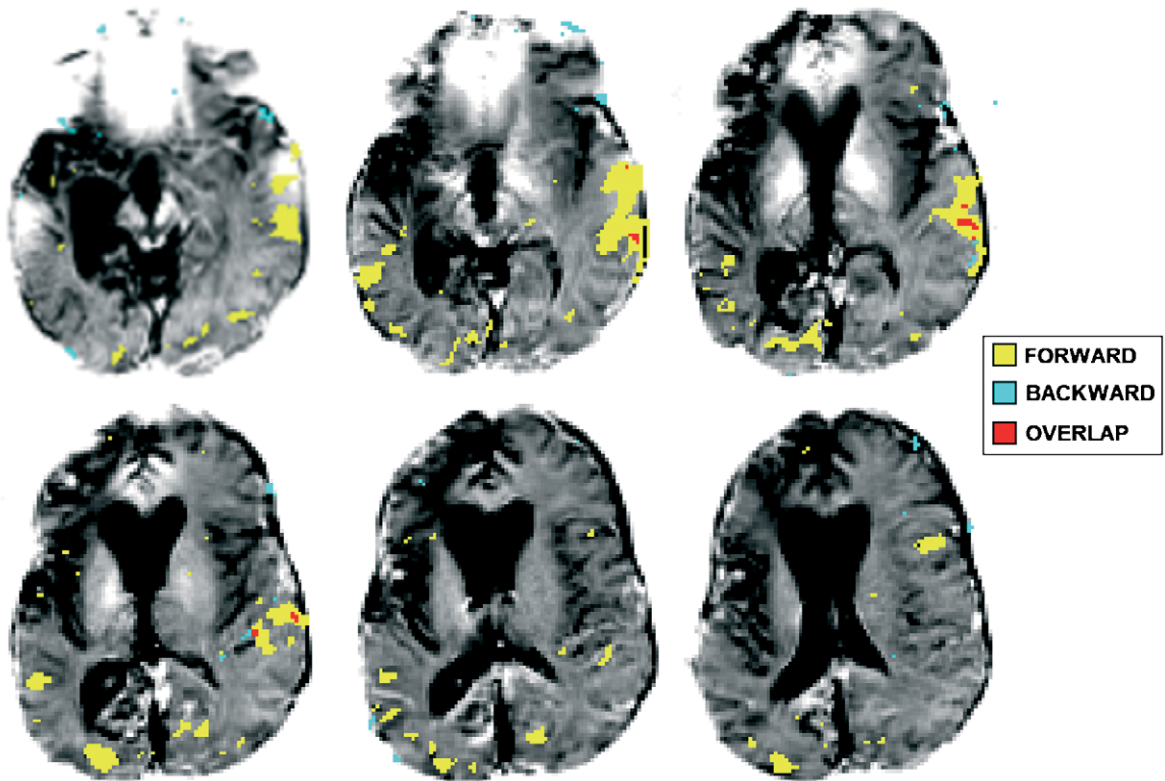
Functional magnetic resonance imaging activation patterns of BOLD signal in response to passive language presentations. Reproduced with permission from MIT Press.
